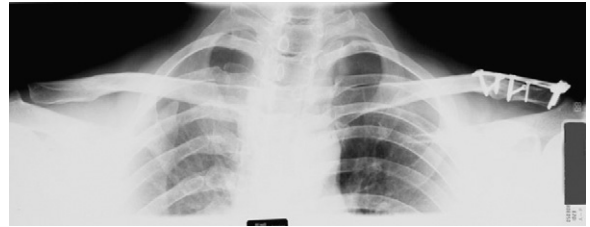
Same case 5 months postoperatively. Stress radiograph with 5 kg axial load, showing bony union and sufficient restoration of vertical stability.
